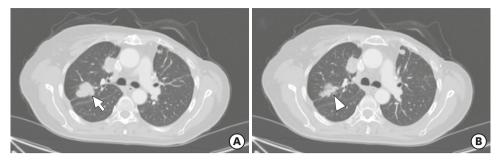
Chest computed tomography (CT) scan before (August 2018) and after (April 2019) the azacitidine (AZA) treatment. (A) Multiple lung metastases (arrow) were found in the chest CT scan. (B) After 4 cycles of AZA, size of right upper lung mass was decreased (arrowhead).
